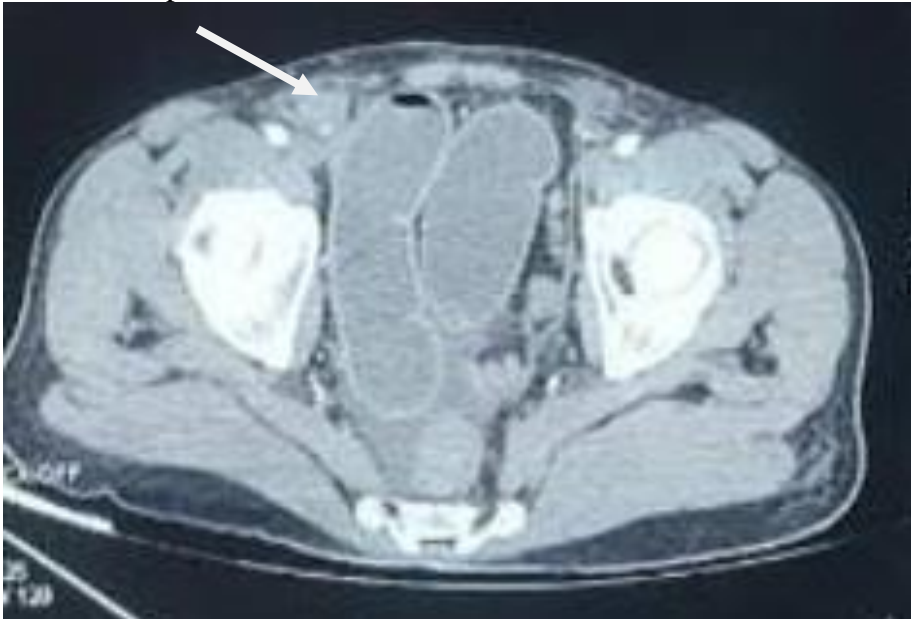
CT scan depicting a bowel loop herniating into inguinal hernia
